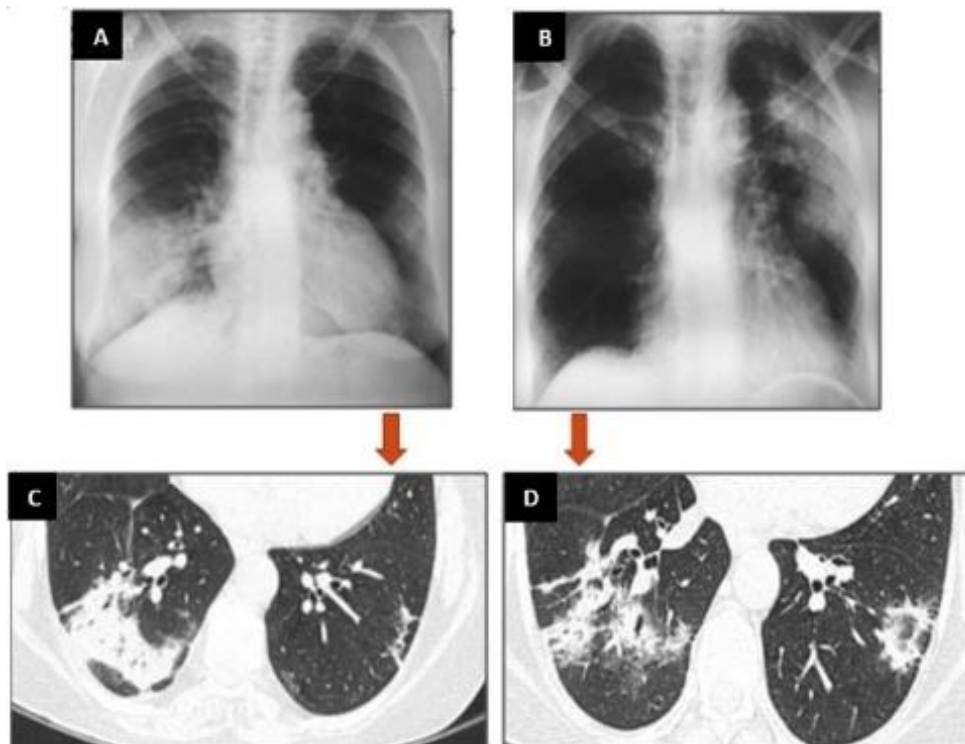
Chest X-ray and computed tomography scan demonstrating curved condensations and reversed halo sign.
